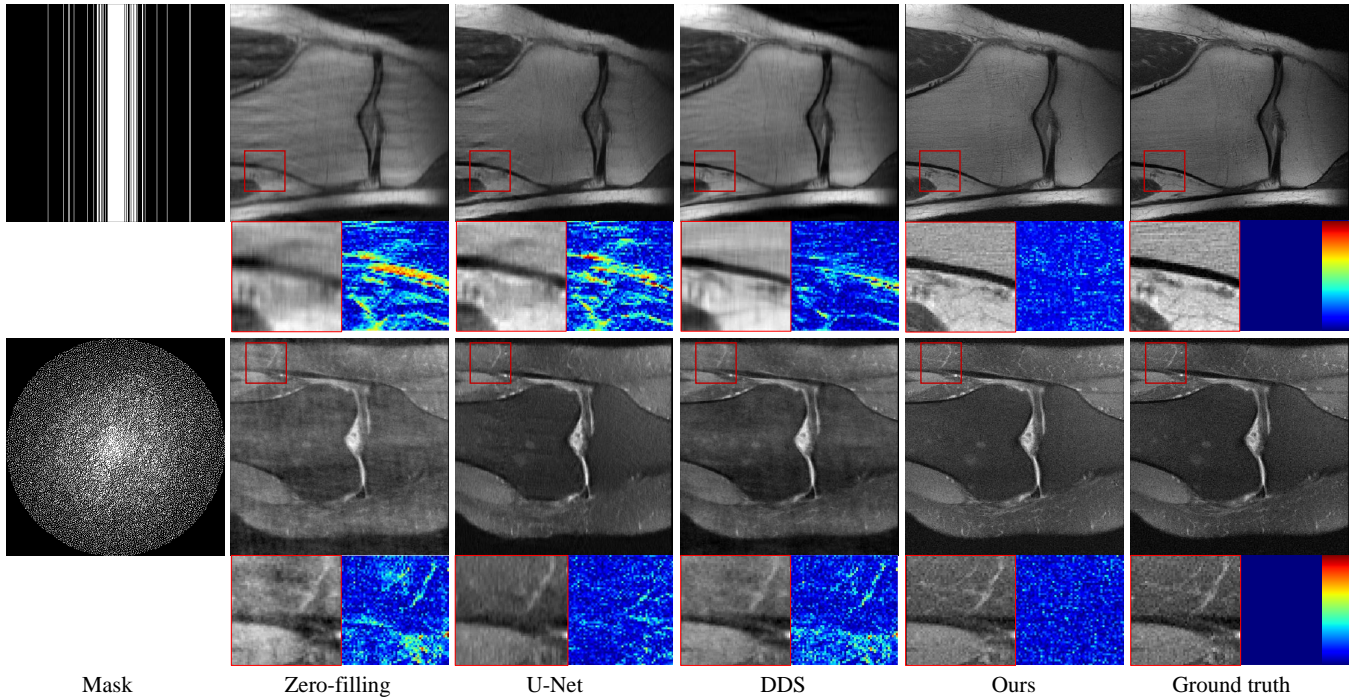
Qualitative results of fast MRI reconstruction.
